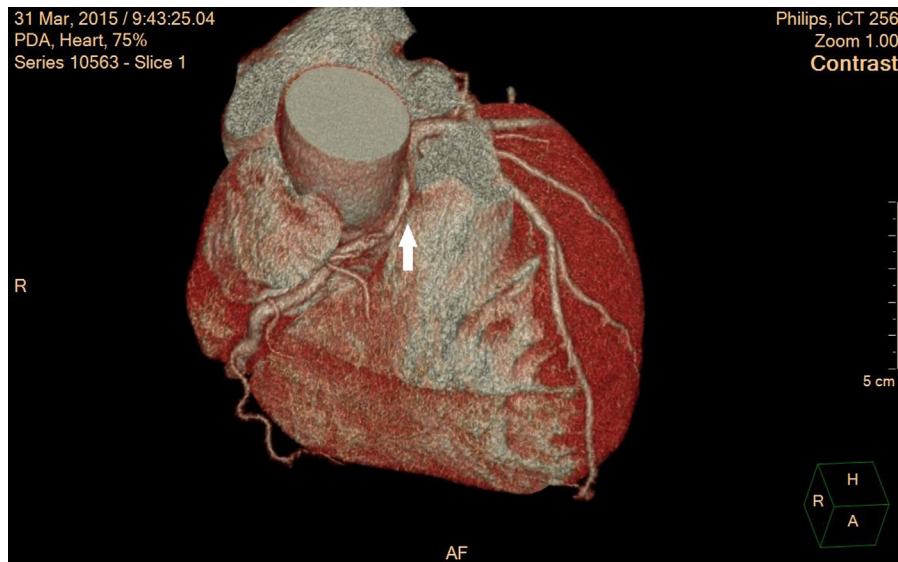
Three-dimensional volume-rendered CT image showing an interarterial course of the right coronary artery originating from the left sinus of Valsalva.
